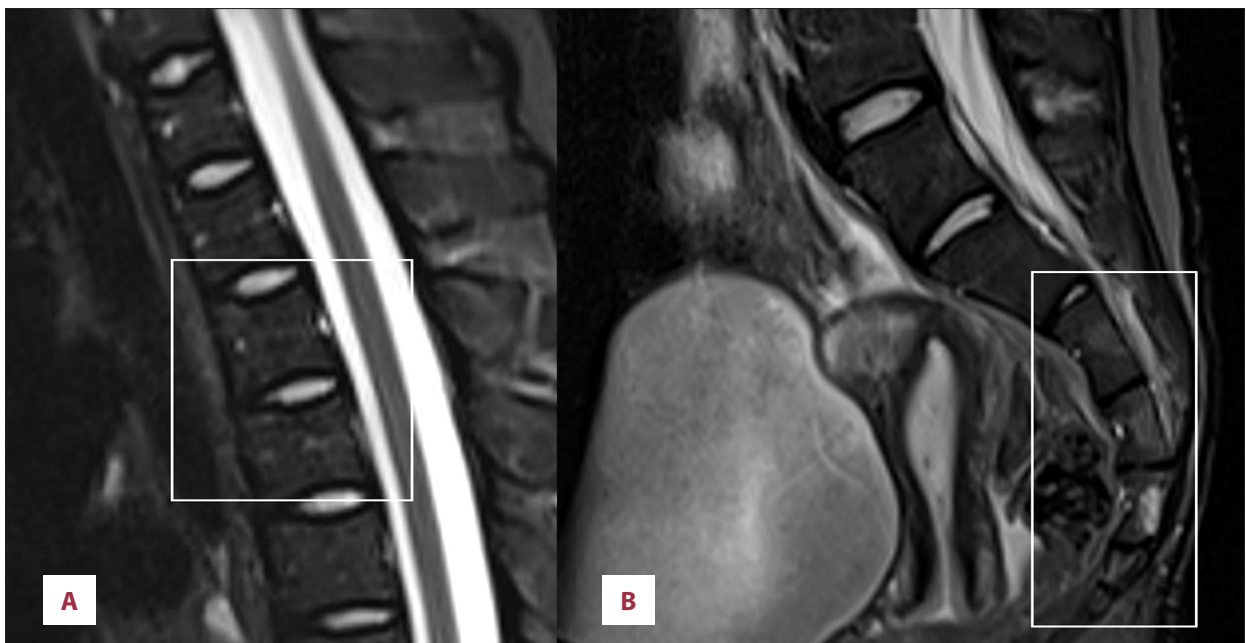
MRI of the thoracolumbosacral spine. (A) Fat-suppression T2 MRI of the thoracic spine showed faint hypersignal intensity at T3 and T4 vertebrae. (B) Fat-suppression T2 MRI of the lumbosacral spine showed strong hypersignal intensity at S4 vertebra and faint hypersignal intensity in S2 and S3 vertebrae.
